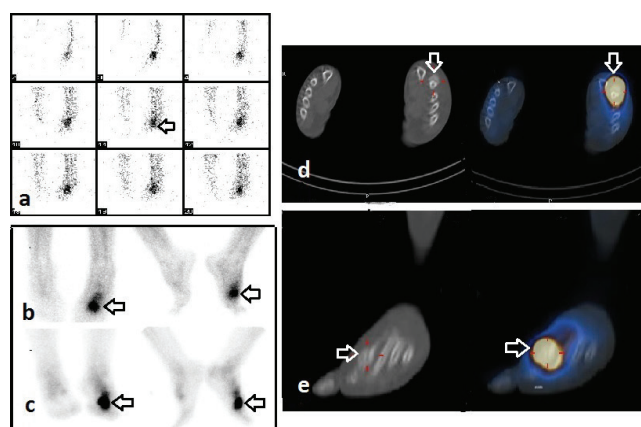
Three-phase PBS of a 56-year-old woman with left foot swelling, pain, and trauma history for 2 years. (A) Perfusion (B) blood pool (C) late static images show slightly increased perfusion, blood pool and osteoblastic activity in left metatarsophalangeal region (arrows). The planar images suggest acute osteomyelitis without single photon emission computed tomography (SPECT)/computed tomography (CT). (D) Axial (E) sagittal CT, and fusion images show fracture site and callus in the distal of second metatarsal bone associated with focal intense increased uptake (arrows). Fracture and callus are confirmed by diagnostic CT
